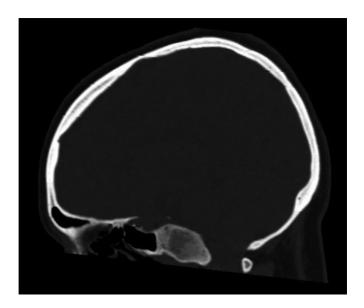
CT head scan sagittal view showing ground-glass appearance of the well-defined, expansile clival lesion.
